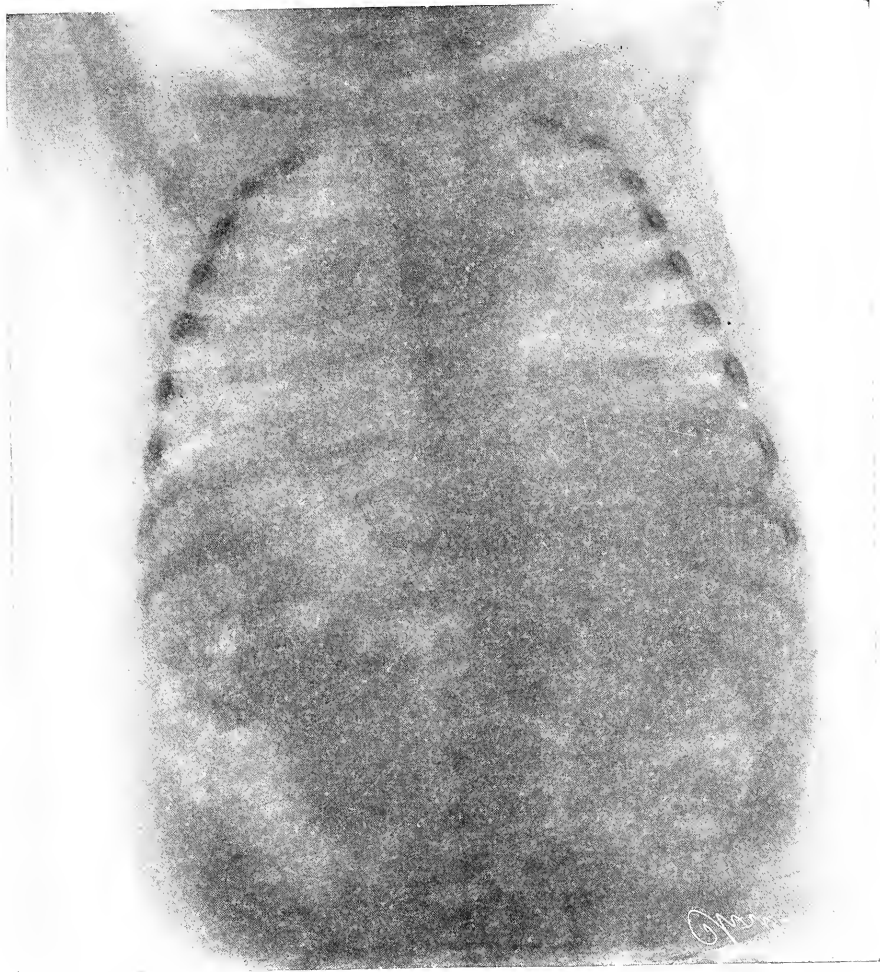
Enlarged thymus. (Roentgenogram by Dr. H. K. Pancoast.)
